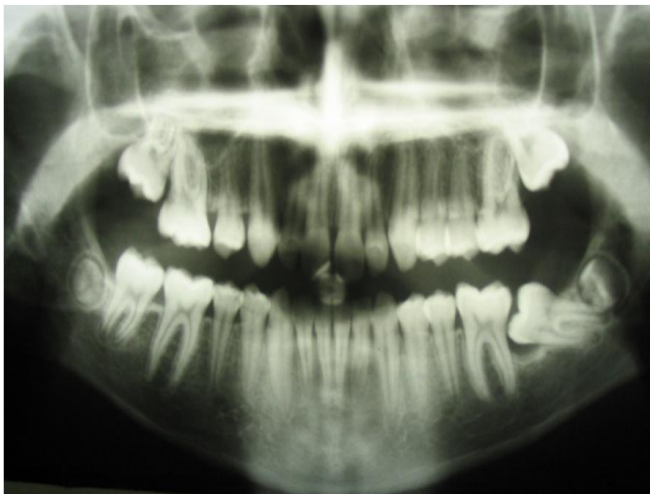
Orthopantomogram : Eruption disorder of the left second lower molar with complete gingival inclusion
